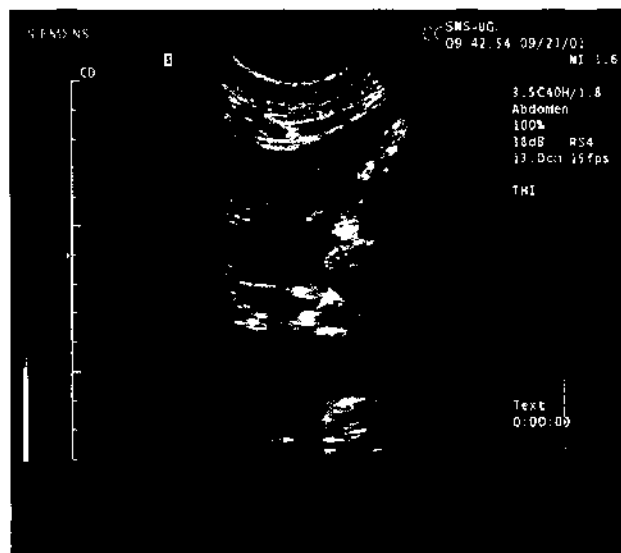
Stone in a dilated common bile duct. The echogenic structure within the dilated common bile duct (arrowhead) is identified as a stone by its shadowing. Dilatation is easily recognized on ultrasound, but stones are often much more elusive and endoscopic retrograde pancreatography may be required.
